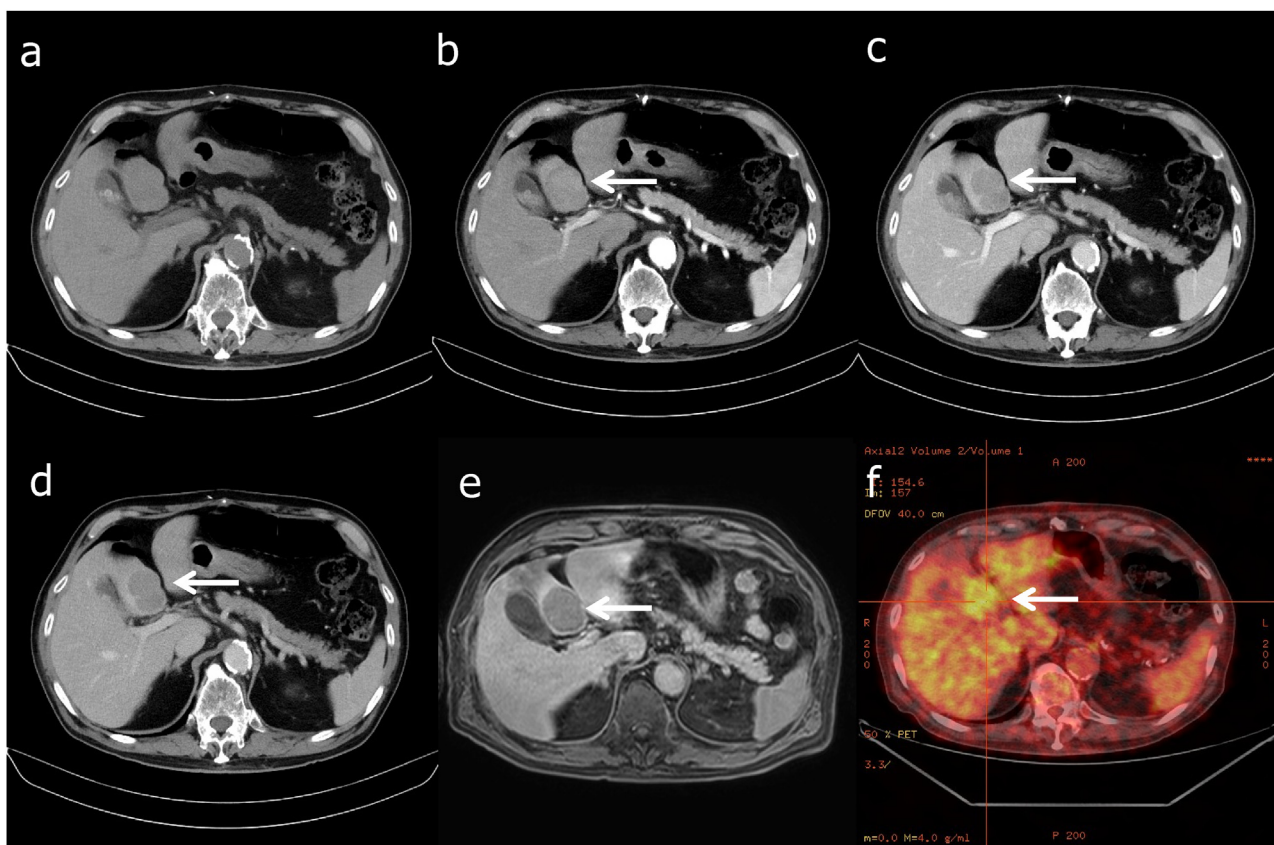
(a–d) Liver dynamic computed tomography (CT). (a) Plain CT, (b) arterial phase, (c) portal phase and (d) delayed phase (arrows). The tumor, located in the segment 4 of the liver, measured 40 mm in diameter. The density of the tumor was well enhanced in the arterial phase and washed-out in the portal phase. (e) The hepatobiliary phase of Gd-EOB-DTPA-MRI shows tumor nodules in the liver with low intensity in segment 4 (arrow). (f) Positron emission tomography-CT. The SUV max of the tumor in S4 of the liver is 3.2 (arrow).
